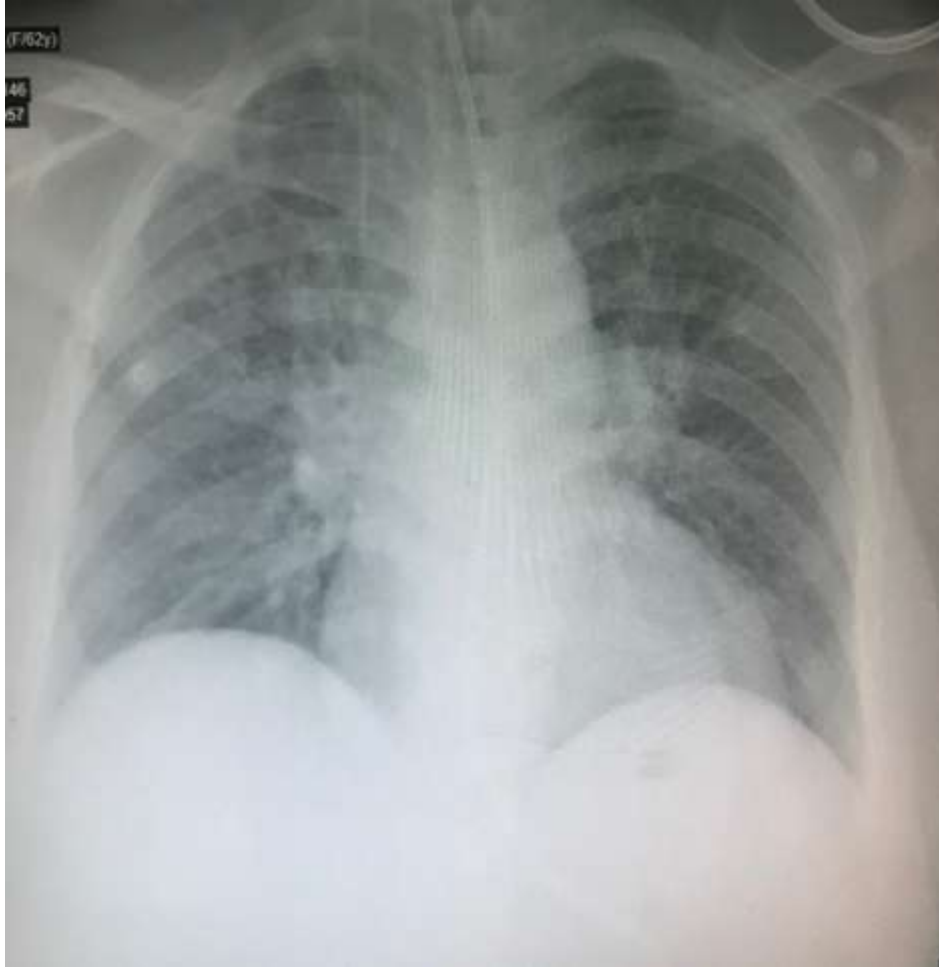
Chest X-ray: bilateral lymphadenopathy.
